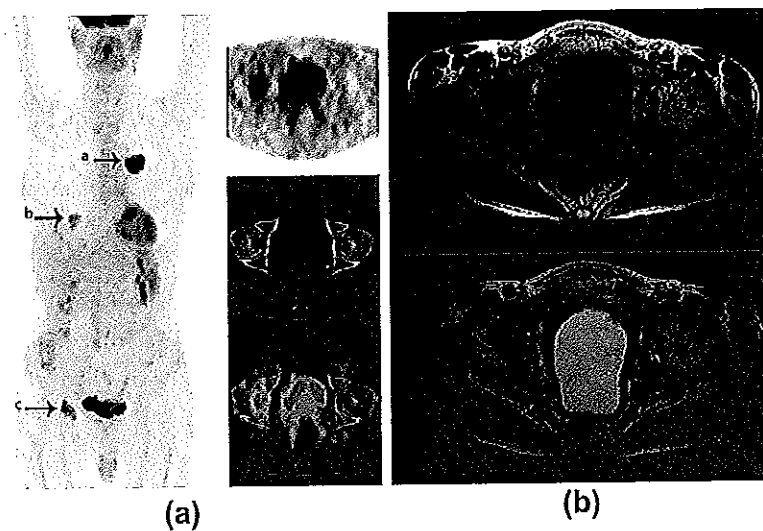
Avascular necrosis of the hip mimicking a bone metastasis. MIP PET image in a patient attending for staging of lung cancer (a) shows a low-grade area of tracer uptake in the right lower lobe (b), which proved to be inflammatory on comparison with previous imaging. In addition, however, there is focal uptake in the right hip (c), which on selected axial PET, CT and fused PET/CT images corresponds to area of osteolysis in the right femoral head involving the fovea capitis. An MRI examination performed subsequently (T1- and T2-weighted, fat-suppressed, axial images shown) demonstrates typical changes of avascular necrosis.
